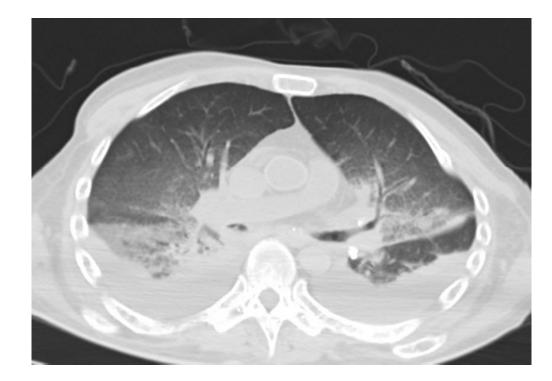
Normal postmortem changes could mask underlying pathology. This patient had a clinical history of allogeneic stem cell transplantation due to multiple myeloma. Clinical examination and antemortem MRI of the brain suggested a post-transplant lymphoproliferative disorder (PTLD). Autopsy diagnosed
